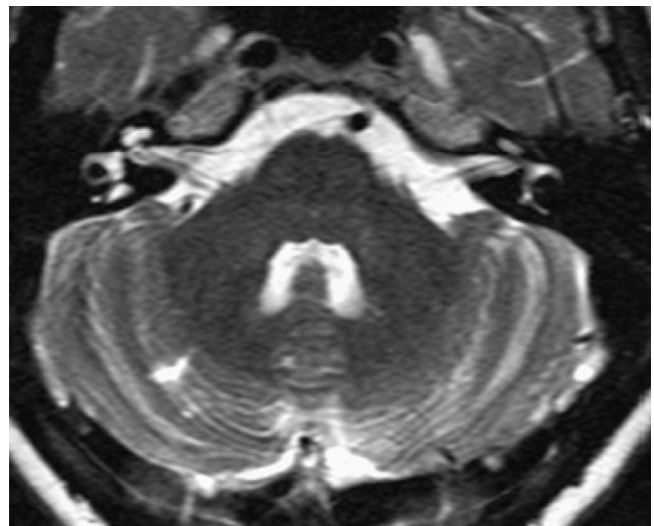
Brain MRI, axial view with CISS sequences.
